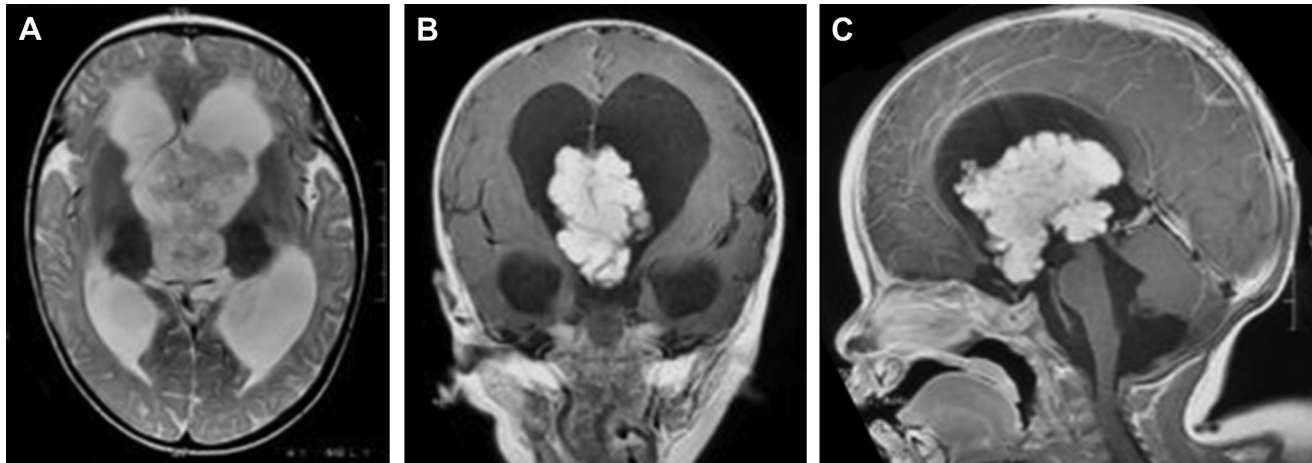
Preoperative magnetic resonance images reveal a large tumor in the third ventricle. (A) T2-weighted image. (B) Coronal contrast-enhanced image. (C) Sagittal contrast-enhanced image.
